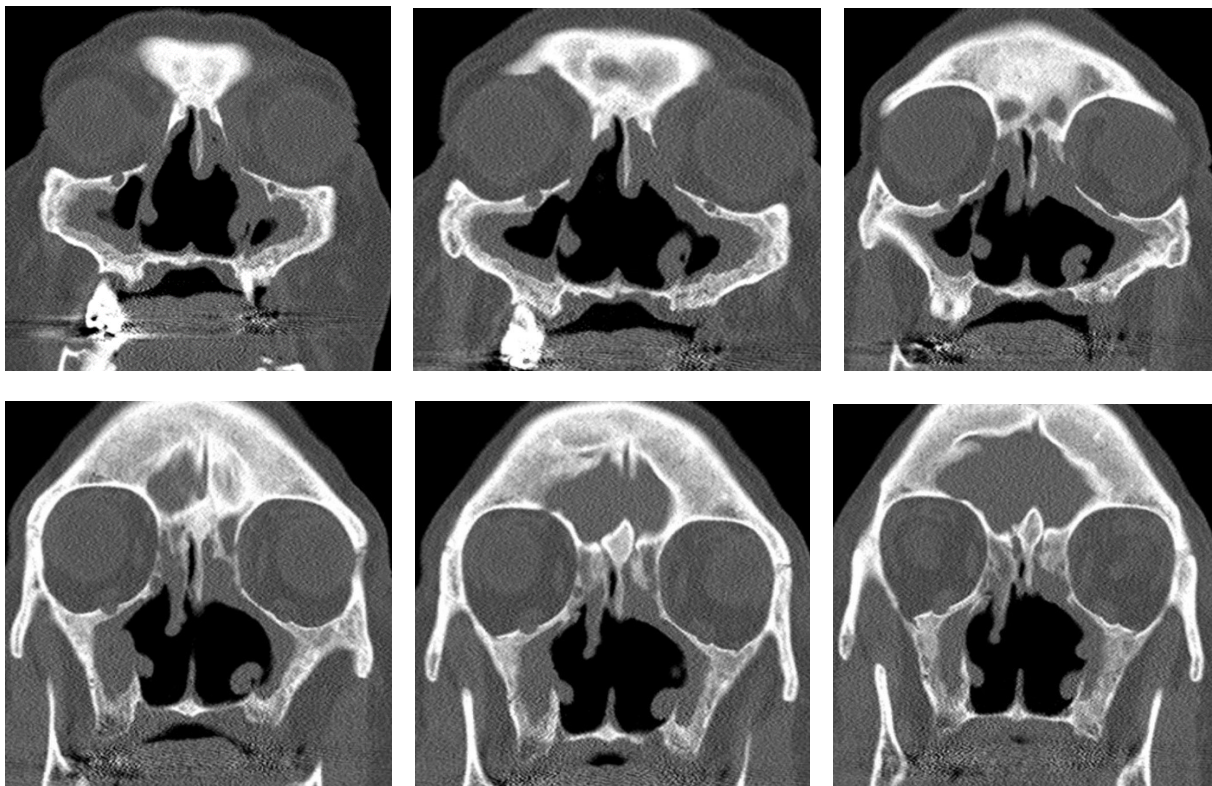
Coronal Sinus CT
